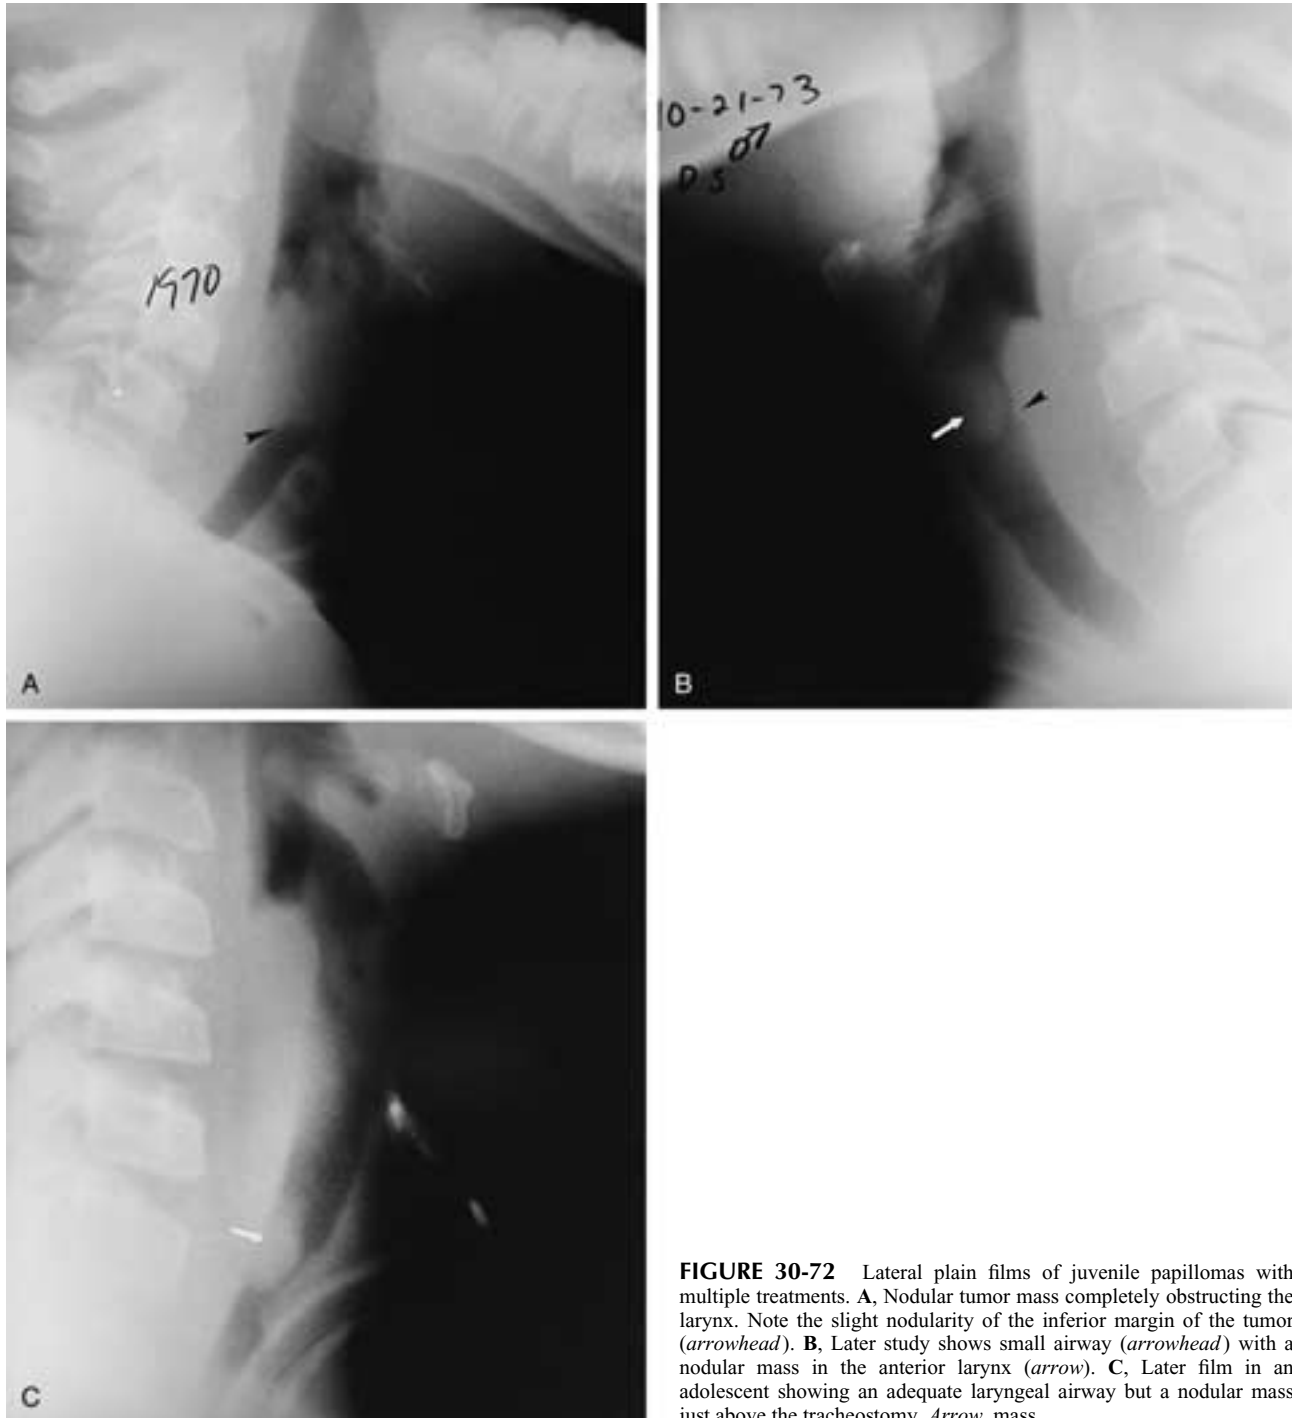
Lateral plain films of juvenile papillomas with multiple treatments. A, Nodular tumor mass completely obstructing the larynx. Note the slight nodularity of the inferior margin of the tumor (arrowhead). B, Later study shows small airway (arrowhead) with a nodular mass in the anterior larynx (arrow). C, Later film in an adolescent showing an adequate laryngeal airway but a nodular mass just above the tracheostomy. Arrow, mass.
